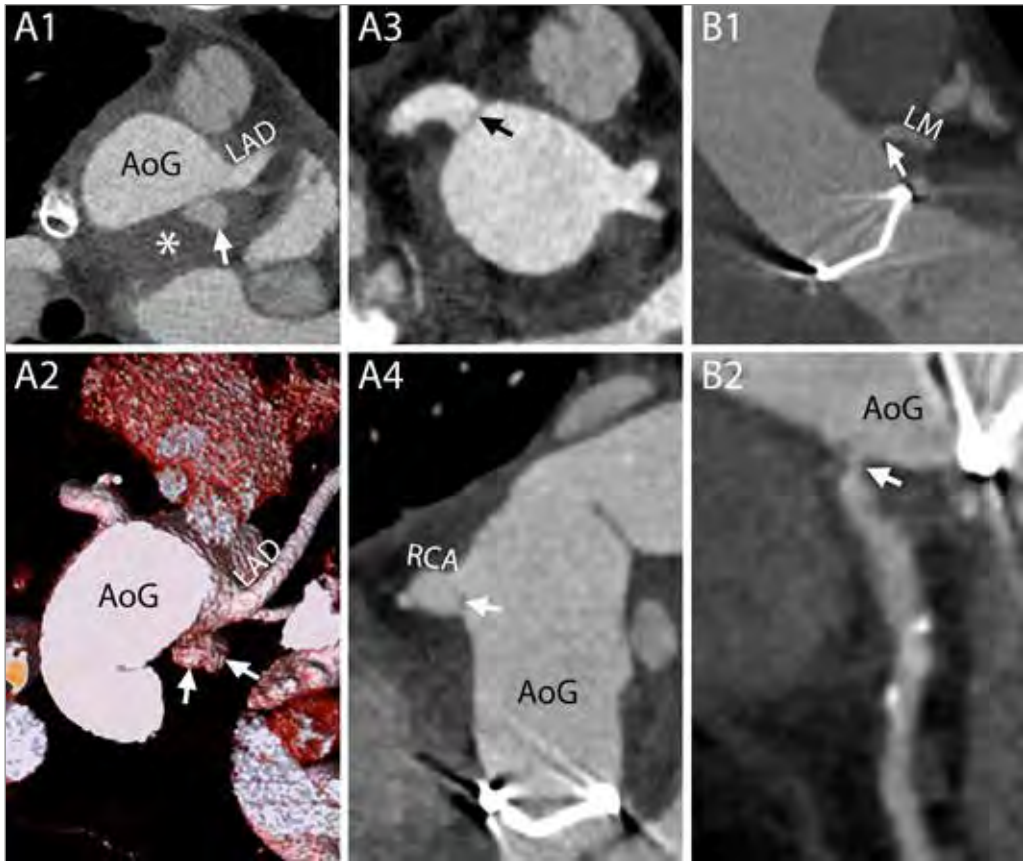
Complications at the site of coronary arteries anastomosis and ostia. A1-A4 – Different complications involving the two coronary arteries in the same patient. On a CT scan performed one month after a Bentall procedure, this 27-year-old man showed signs of complications at both coronary arteries. At the level of the suture line of the left main, a small collection of extravasated contrast material (A1 and A2, arrows) surrounded by a hematoma (A1, asterisk) was identified. The right coronary artery, that had to be re-attached a second time to the aortic graft due to bleeding from the first suture, presented a hypodense line at the ostium (A3 and A4, arrows) that could be attributed to a small intimal flap or to an inward fold of the graft. No invasive or surgical treatment was undertaken. A1 - Axial mage. A2 - VR. A3 - MPR perpendicular to the centerline of the aorta. A4 - MPR parallel to the centerline of the aorta. B1-B2 – Stenosis of the coronary ostium. On a routine follow-up CT scan performed five months after the procedure, this 60-year-old man showed a stenosis of the left coronary artery (B1 and B2, arrows). B1 - MPR parallel to the centerline of the aorta. B2 - CPR. AoG – aortic graft, LAD – left anterior descending, LM – left main, RCA – right coronary artery.
